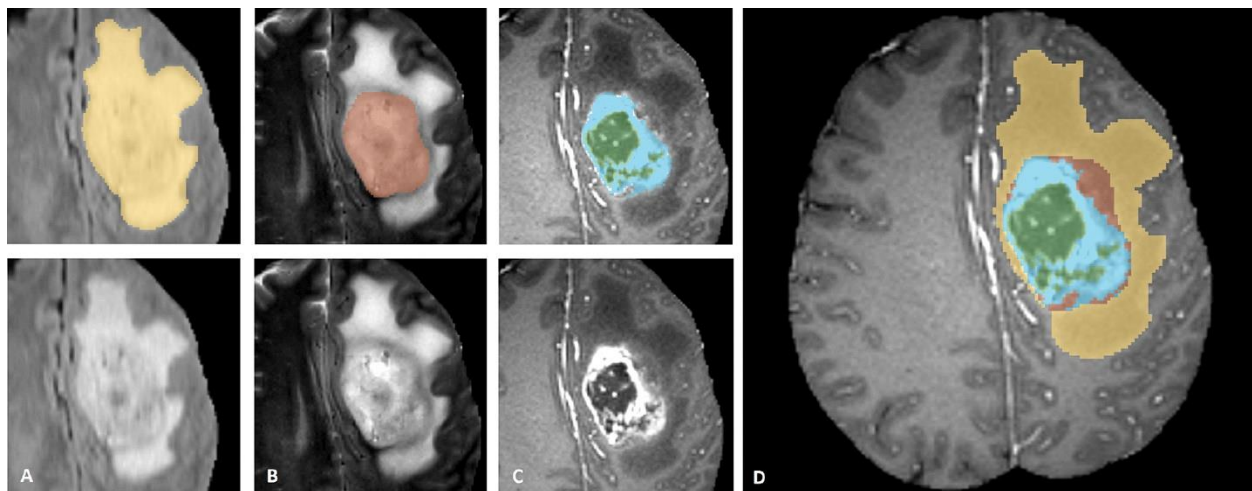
Example of a large brain tumour (bottom row) accompanied by the manual segmentations (top row) of different components of the tumour (edema (yellow), non-enhancing solid core (red), necrotic/cystic core (green), enhancing core (blue)). Notice that different modalities show the different components of the tumour better than others. A) The whole tumour visible in FLAIR. B) The solid core visible in T₂-weighted scan. C) The necrotic (green) and enhancing (blue) visible in T₁-weighted contrast enhanced scan. D) All components combined. (Image taken from “The Multimodal Brain Tumor Image Segmentation Benchmark (BRATS)” by Menze *et al.*[153]).
